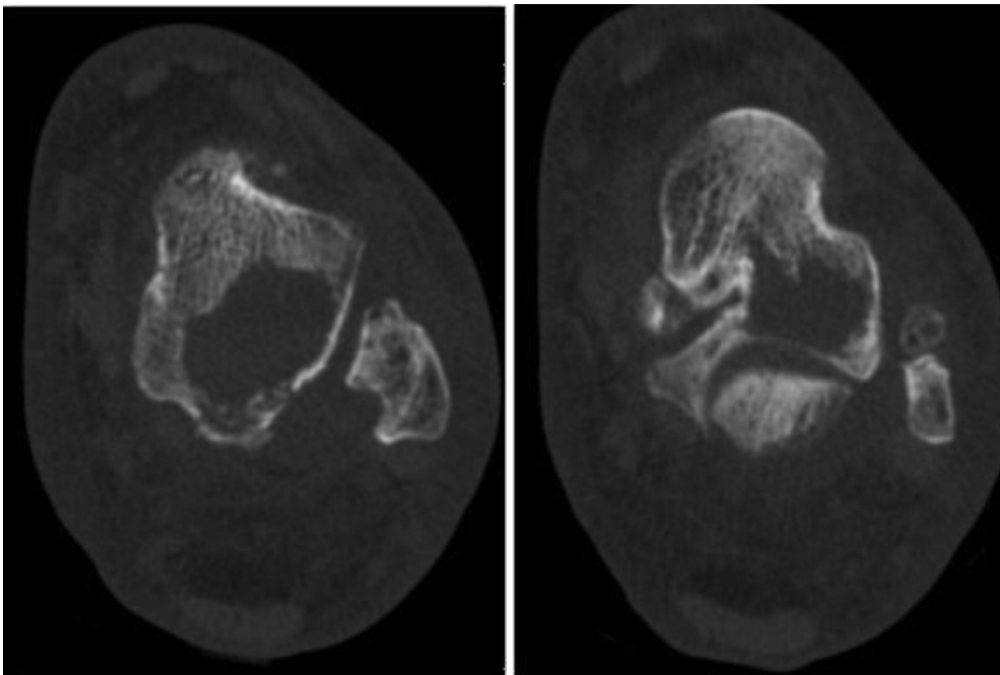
Axial computed tomography image of the left ankle.
